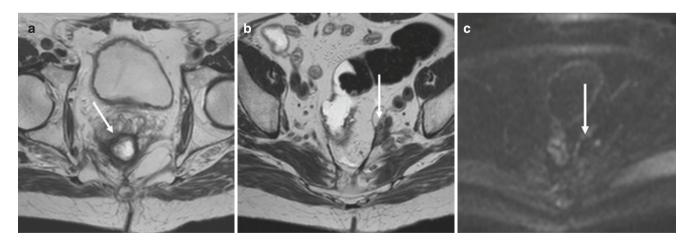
MRI of T3b tumor with posttreatment regression. (a) Axial T2 image shows a rectal cancer with focal extension beyond the outer muscular layer (T3b) (white arrow). (b) Axial T2 image after treatment of a tumor shows T2 dark signal at the original tumor site from fibrosis (tumor regression grade 2) (white arrow). (c) The same patient had a
